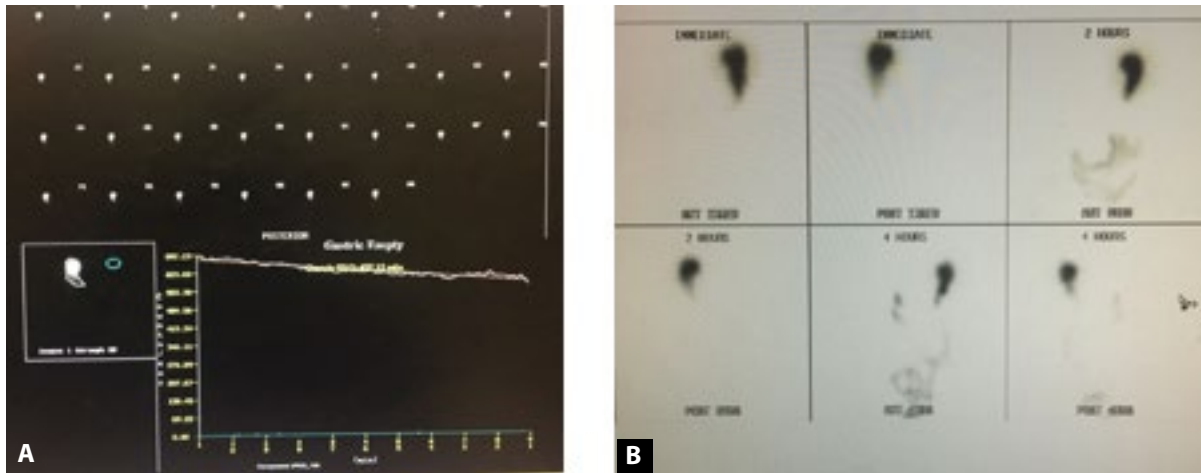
Data (A) and image (B) acquisition of gastric emptying scintigraphy. During this study, the geometric mean of radiotracer activity was 74,277 counts at 2 hours, which corresponds with a 72% retention rate. At 4 hours, the geometric mean of radiotracer activity was 56,188 counts, which corresponds with a 55.1% retention rate and is delayed compared with normal gastric emptying.
